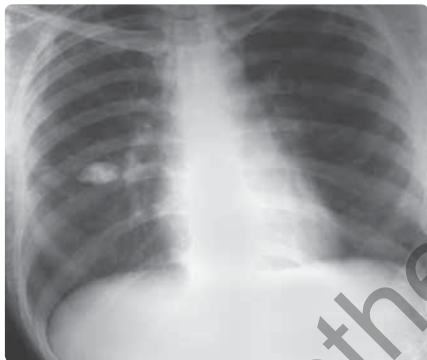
Chest X-ray PA view showing solitary pulmonary nodule with popcorn calcification
